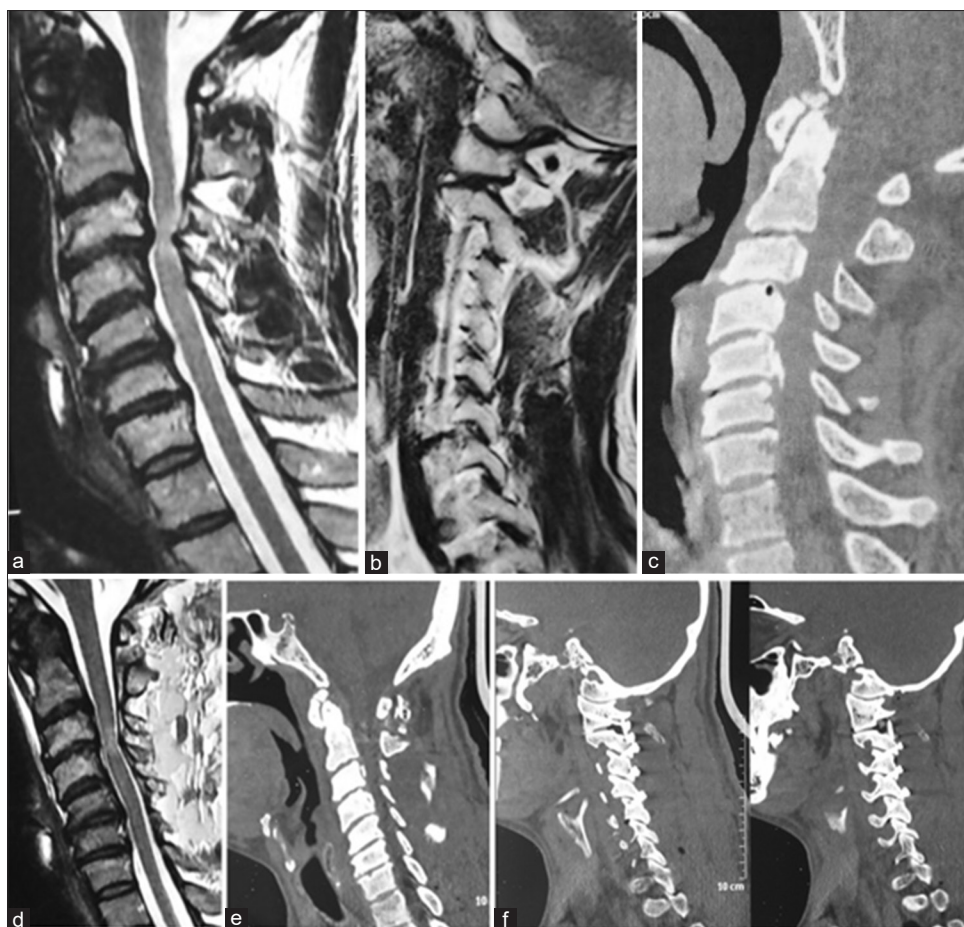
Images of a 52-year-old male patient. (a) T2-weighted magnetic resonance imaging shows evidence of cervical spondylosis. (b) Magnetic resonance imaging showing type 2 atlantoaxial facet instability. (c) Computed tomography scan shows normal atlantodental interval. (d) Postoperative Magnetic resonance imaging 12 months after surgery shows reduction in size of osteophytes and related cord compression. (e) Postoperative computed tomography scan. No bone decompression is done. (f) Postoperative computed tomography scan showing C1-2, 2-3, 3-4, and 4-5 fixation
